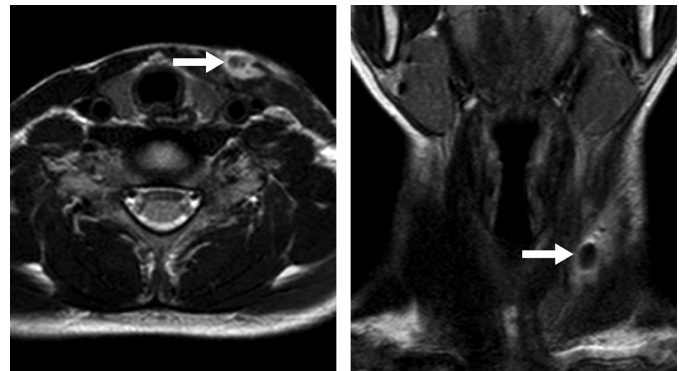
The child came to our attention several months later for a recurrence of left cervical swelling with neck fistulization (arrow). MRI with gadolinium showed a neck abscess on the left side. MRI, magnetic resonance imaging.
